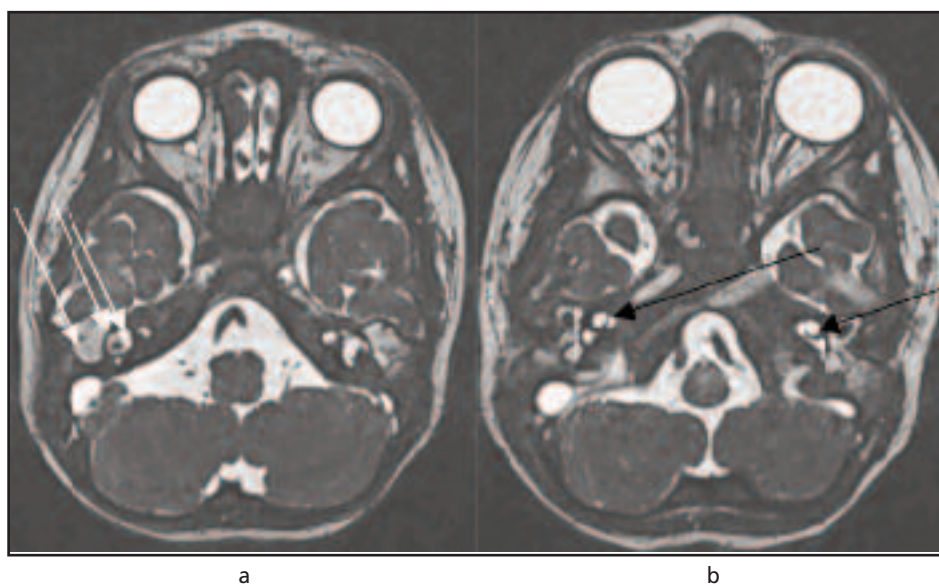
MRI internal auditory meatus a) demonstrates effusion within bilateral middle ear cavity, normal vestibule and lateral semi-circular canal (white arrow) b) depicts bilateral normal cochlear (black arrow).
